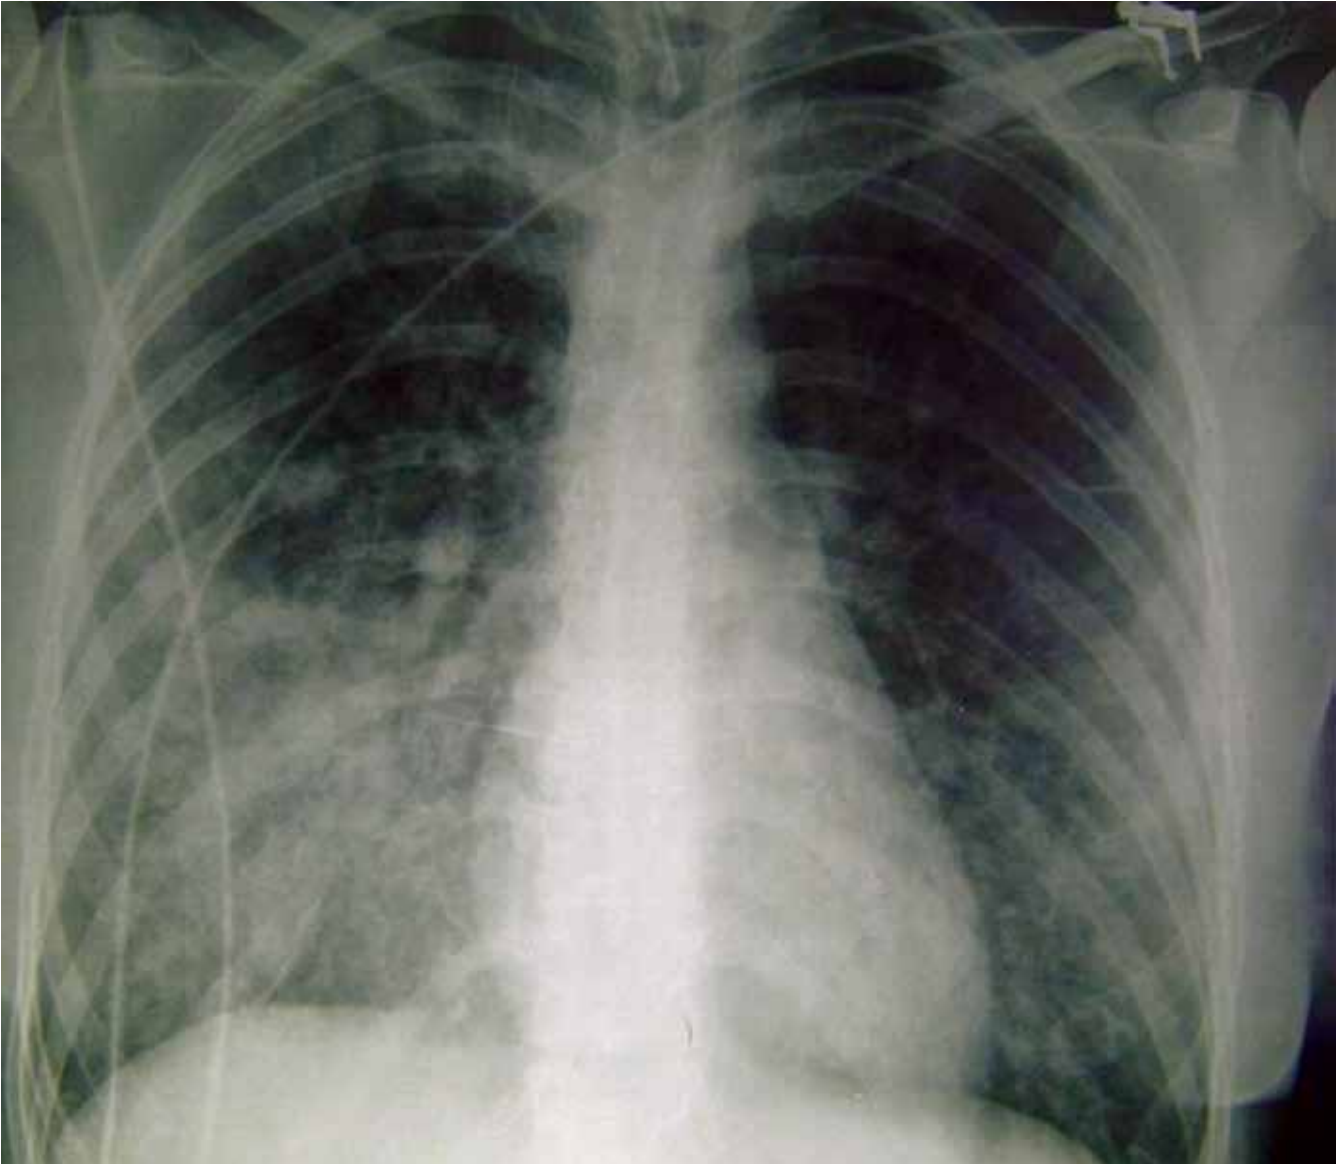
Chest radiography on admission to ICU.
